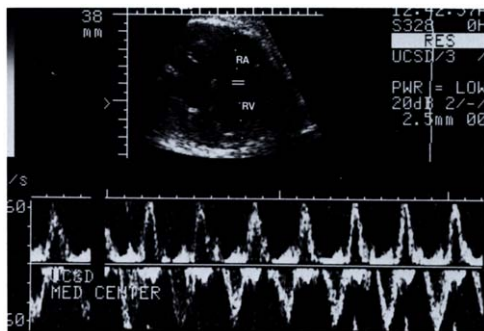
Case 18. Two-dimensional echocardiogram and pulsed Doppler recording obtained in a 28 week old fetus with an unguarded tricuspid valve orifice, showing low velocity bidirectional flow between the right atrium (RA) and right ventricle (RV). By pulsed Doppler ultrasound (below), systolic and diastolic flow velocities across the markedly dilated tricuspid valve annulus are essentially identical and no tricuspid leaflet tissue is visible in the two-dimensional image (above).
